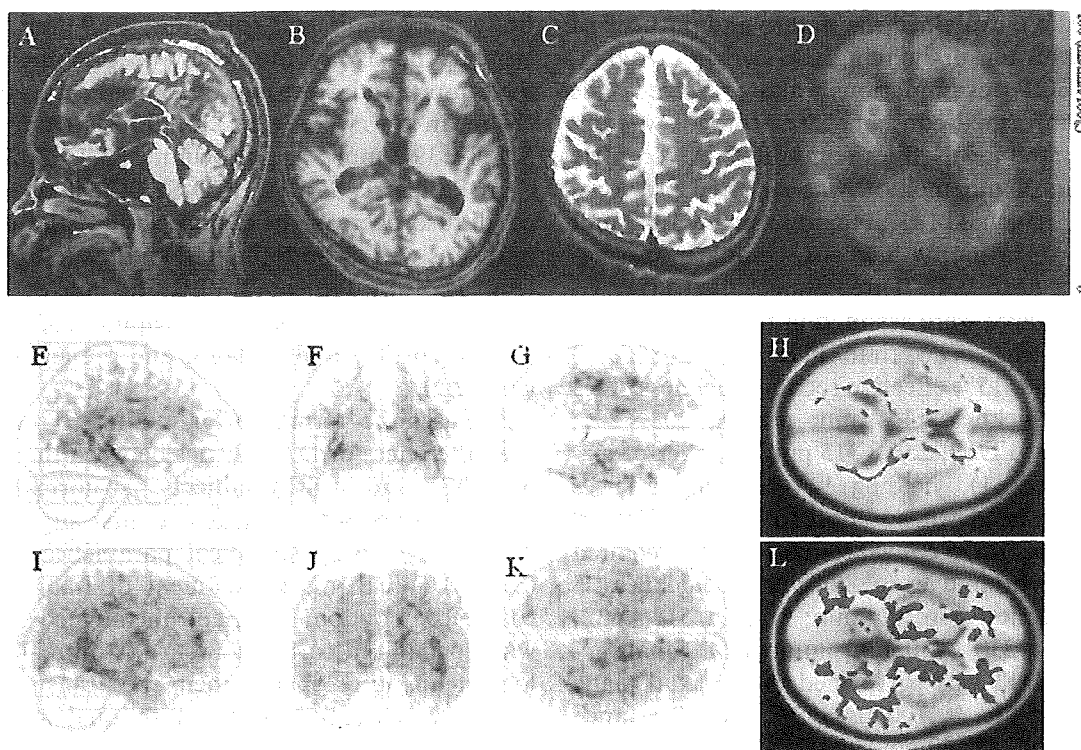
Patient 1, a 27-year-old man with familial spastic paraplegia. A: Sagittal T₁-weighted image shows extremely thin corpus callosum (CC). B: Axial T₁-weighted magnetic resonance (MR) image shows frontal, temporal cortical atrophy. The trigones of the lateral ventricle are dilated. C: Axial T₂-weighted MR image shows subtle high intensity in the atrophic frontal and parietal white matter. D: Single photon emission computed tomography (SPECT) image shows diffuse decrease in blood flow in the cerebral cortex as well as both thalami and the left putamen. E-H: The decreased region of fractional anisotropy (FA) value depicted on the standard normalized space (2-sample t-test, statistical parametric mapping [SPM] 2). Significantly low FA values were detected in the thalamus and almost the entire cerebral white matter. I-L: The increased region of mean diffusivity (MD) value is shown. Similar to FA study, significantly high MD is revealed.
